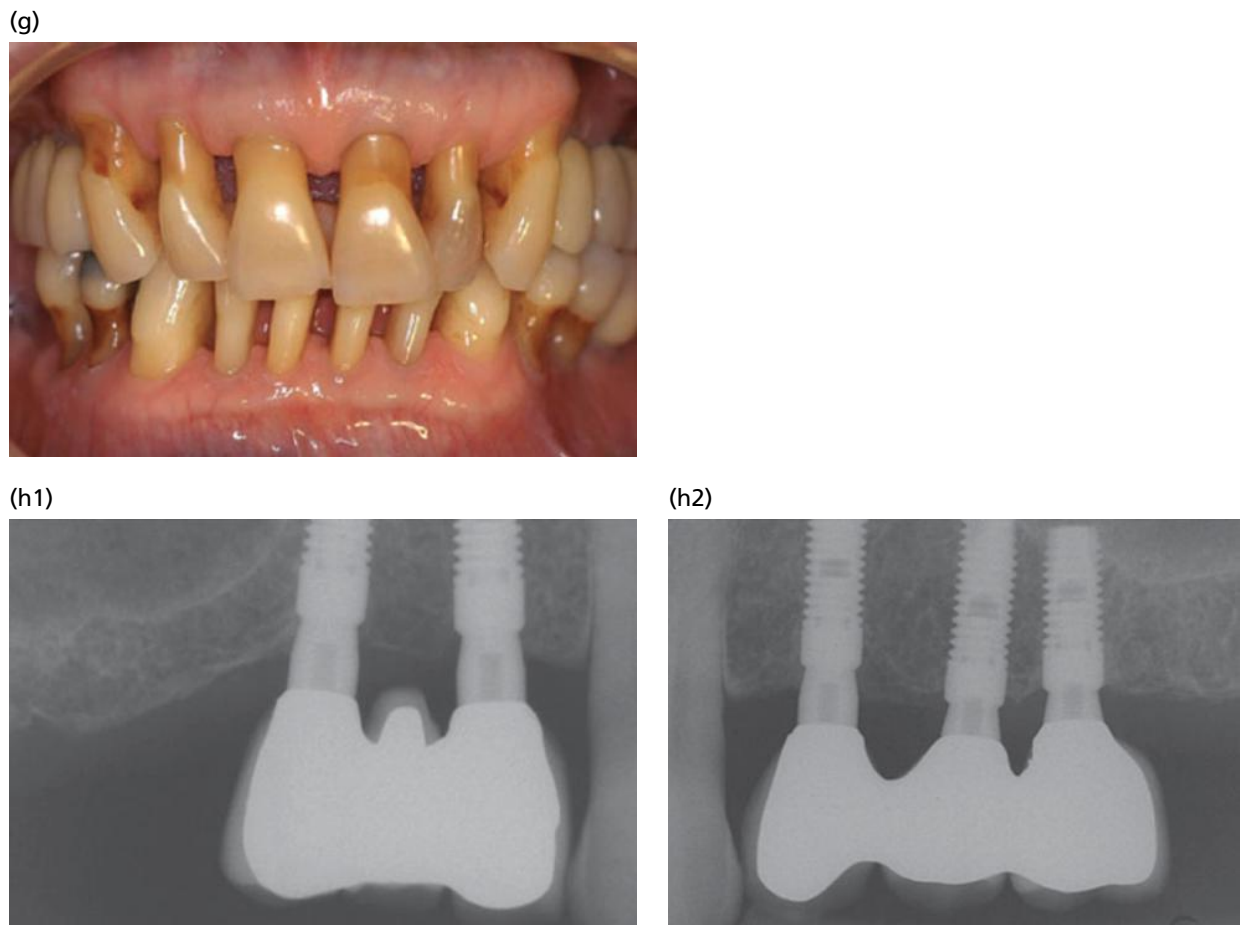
(Continued) (g, h) Clinical and radiographic status 10 years after completion of the implant treatment. Note that there is no loss of bone support at the implants.
